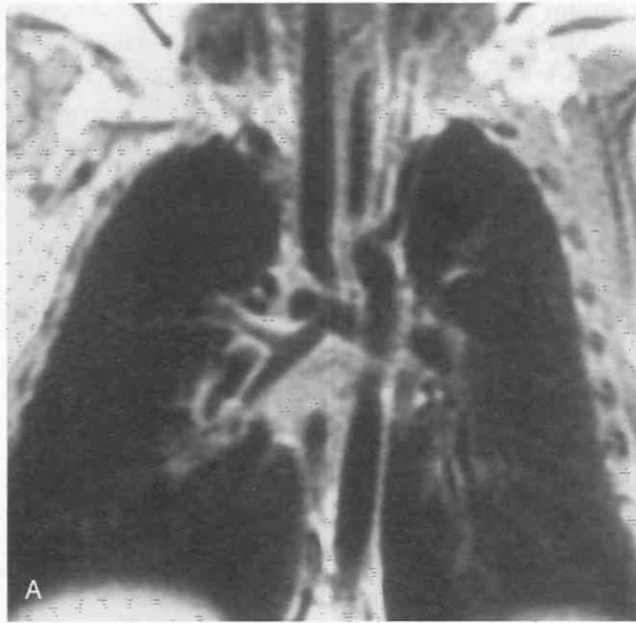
Respiratory distress in a 1-month-old infant. Coronal (A) and axial (B) cross-sectional echocardiographic images show the aberrant origin of the left pulmonary artery from the right. Airway narrowing is also noted.
